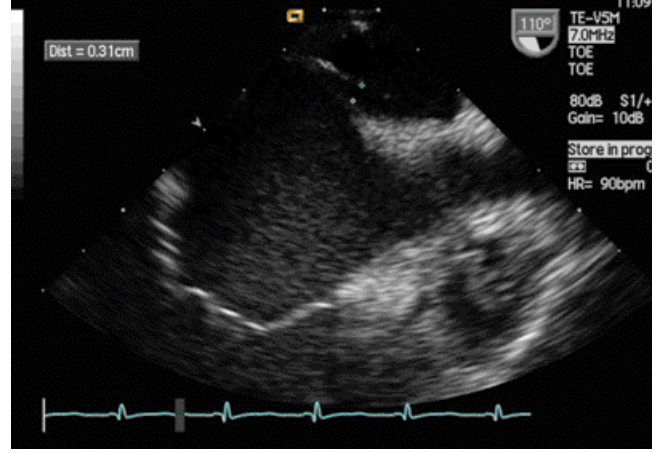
Transoesophageal echocardiogram of an interatrial septum showing a patent foramen ovale measuring 3.1 mm in dimension (using calipers).
